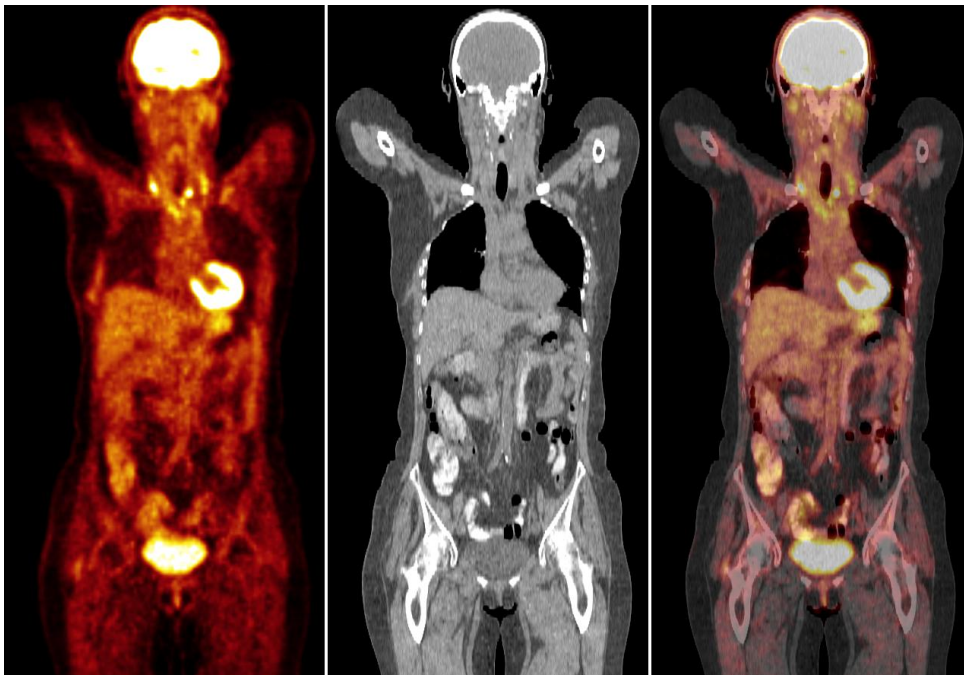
Coronal views of PET, CT and fused PET/CT from a patient with bronchial carcinoma examined with ^{18}F -FDG on a PET/CT scanner. Increased focal ^{18}F -FDG uptake allows the localization of the lesions throughout the body.
